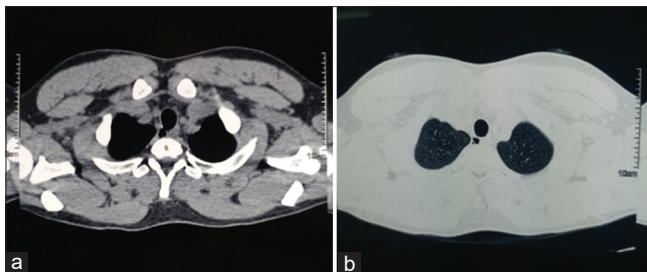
High-resolution computed tomography of chest showing (a) defect in the trachea and (b) air in the mediastinum (pneumomediastinum)
